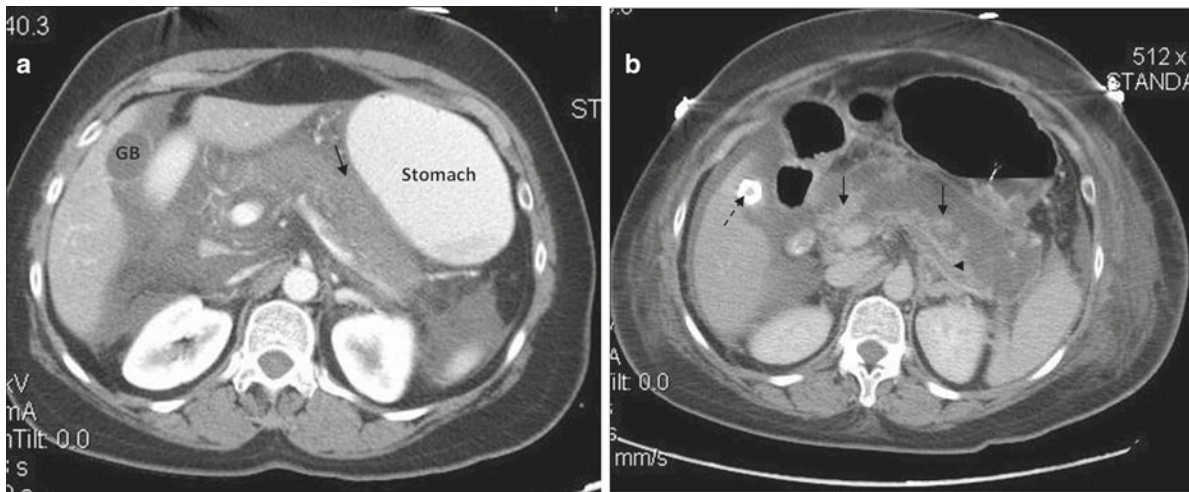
A 69-year-old woman with severe upper abdominal pain and hypotension. (a) On day 1: axial oral and intravenous contrast enhanced CT image through the upper abdomen shows relative lack of enhancement of the pancreas (see normal Fig. 25.34). There is peripancreatic fluid and ascites (solid black arrows). A gallstone is not visualized within the GB (gallbladder). (b) On day 9: axial oral and intravenous
